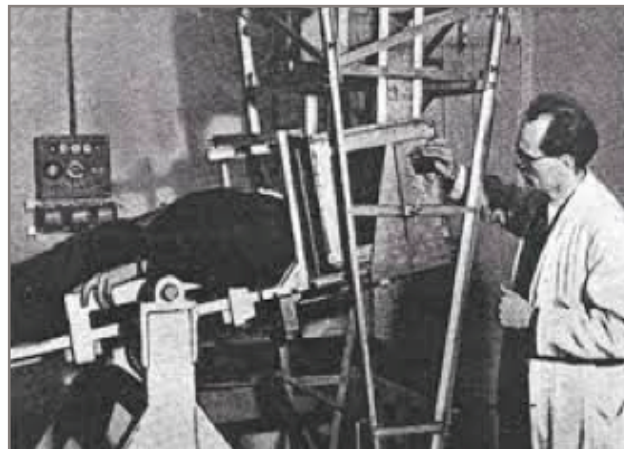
The first ultrasound machine in 1942. Taken from Sudol-Szopincka et al. History page: Leaders in MSK Radiology Karl Dussik. Seminar in musculoskeletal radiology, 25. (1) 2021. Thieme Medical Publishers..
